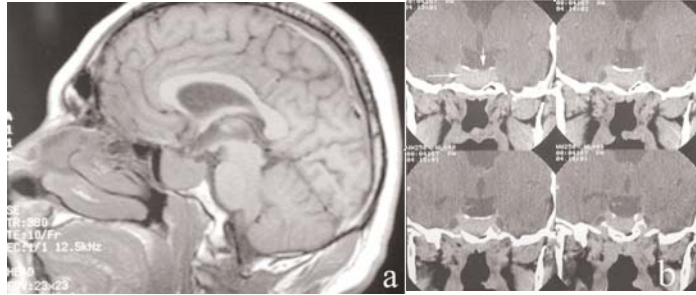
Large pituitary macroadenoma with optic chiasma syndrome in a 37 y aged man. Sagittal (a) and coronal (b) MRI.
